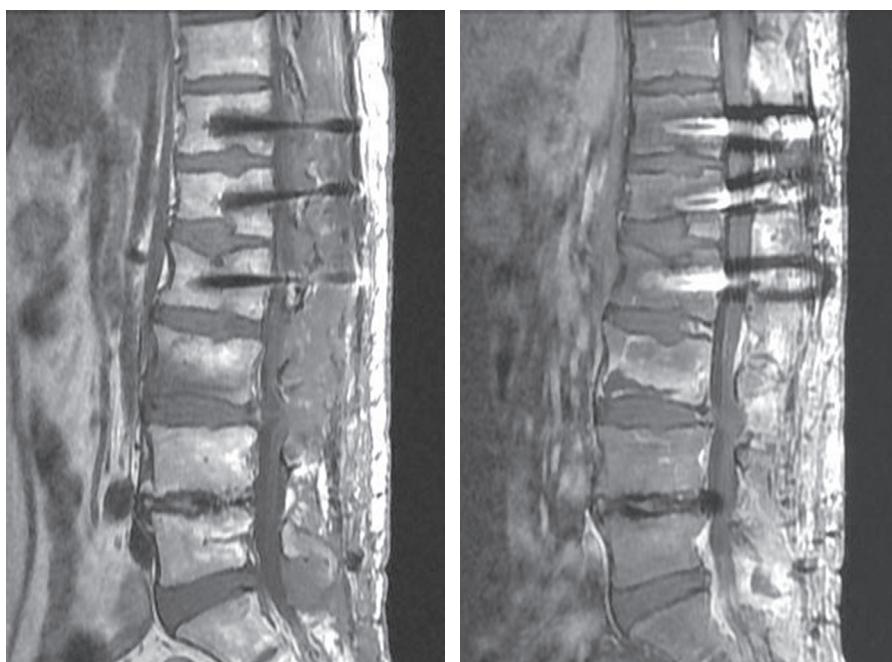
At 5 weeks after surgery, a compression fracture was observed at the inferior end plate of L3 on (Left) T1-weighted and (Middle) gadolinium-enhanced sagittal lumbar magnetic resonance images and (Right) gadolinium-enhanced axial L3 images.
